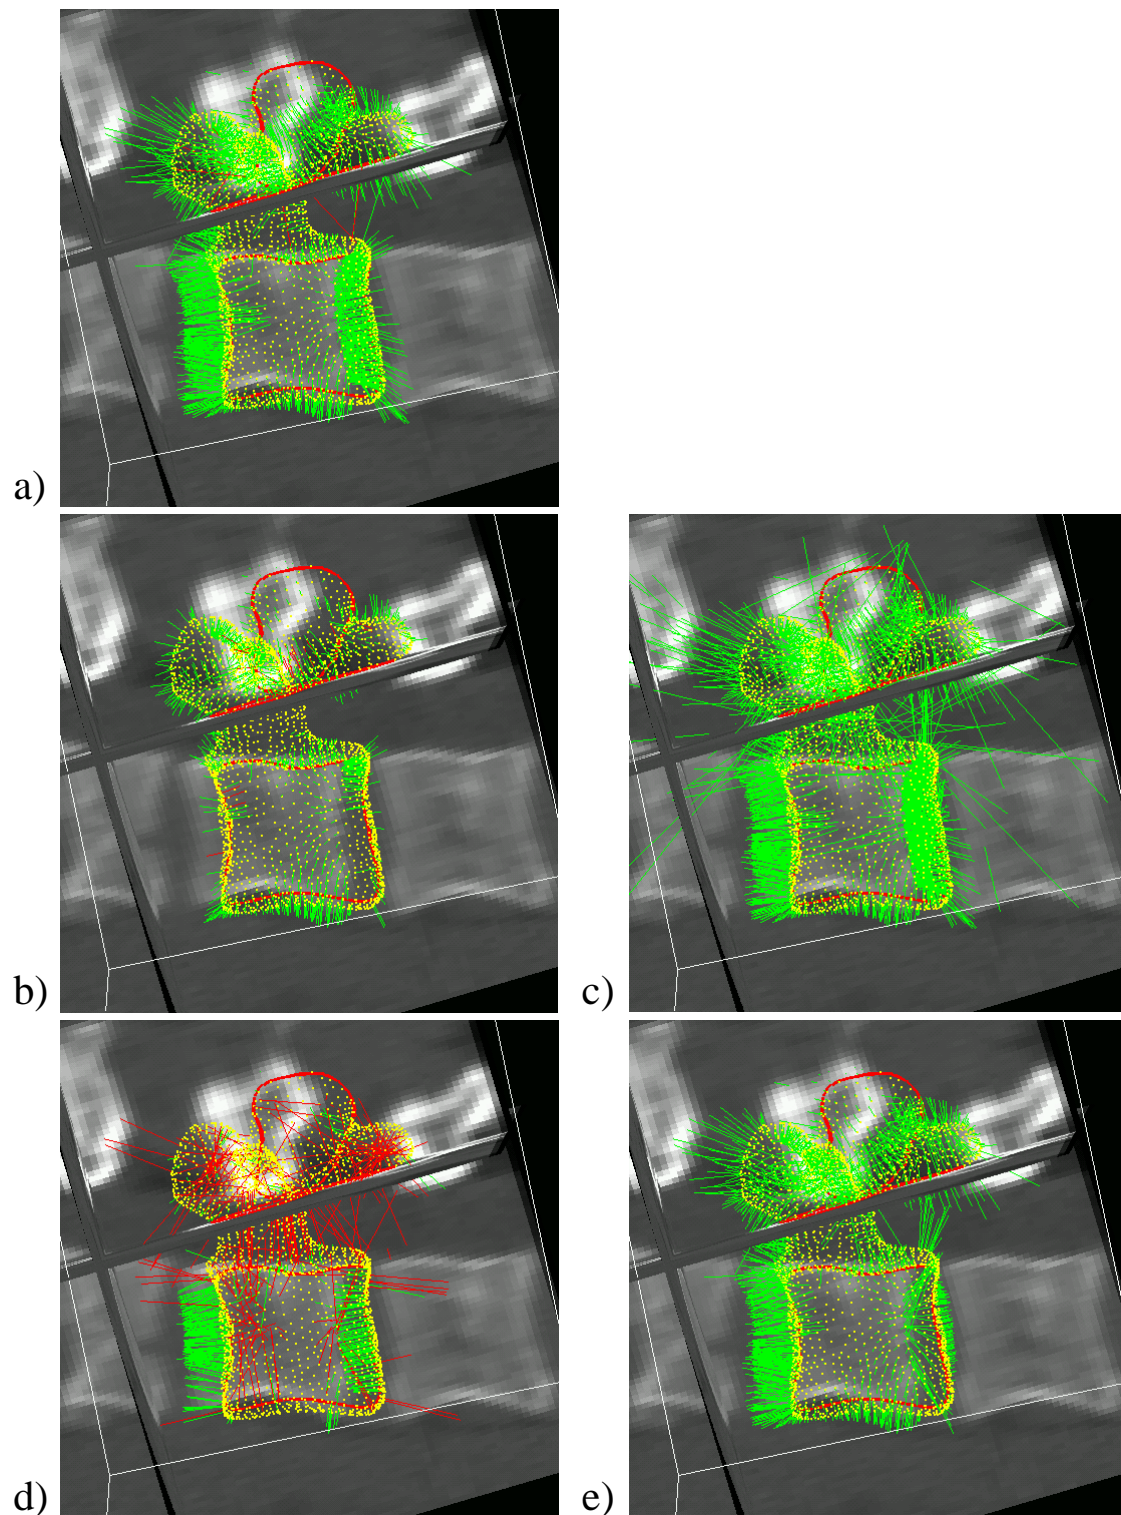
The generic shape model (yellow points) and its corresponding points in a CT image for different values for Δ_{range} and Δ_{angle} . (a) $\Delta_{range} = 15mm, \Delta_{angle} = 90^\circ$, (b) $\Delta_{range} = 5mm, \Delta_{angle} = 90^\circ$, (c) $\Delta_{range} = 100mm, \Delta_{angle} = 90^\circ$, (d) $\Delta_{range} = 15mm, \Delta_{angle} = 15^\circ$, (e) $\Delta_{range} = 15mm, \Delta_{angle} = 180^\circ$
